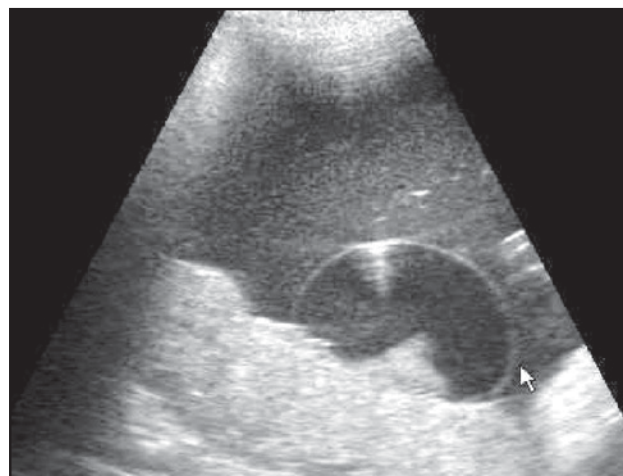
Sonogram of a large placental cyst. Image from the author's teaching files.
